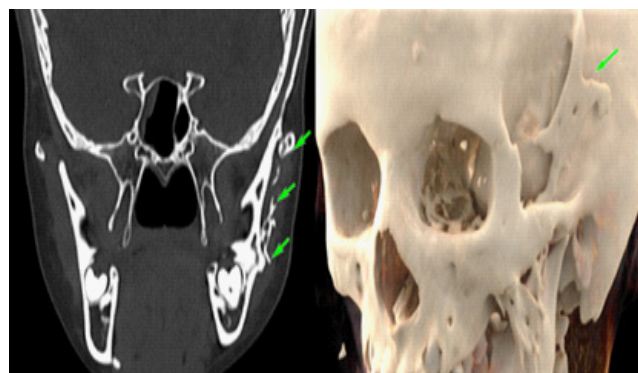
(a) CT (bone window) face in coronal view and (b) VRT image in oblique view show an irregular band of heterotopic ossification within soft tissues of the left temporal region, extending over the mandibular condyle (highlighted by green arrows).
